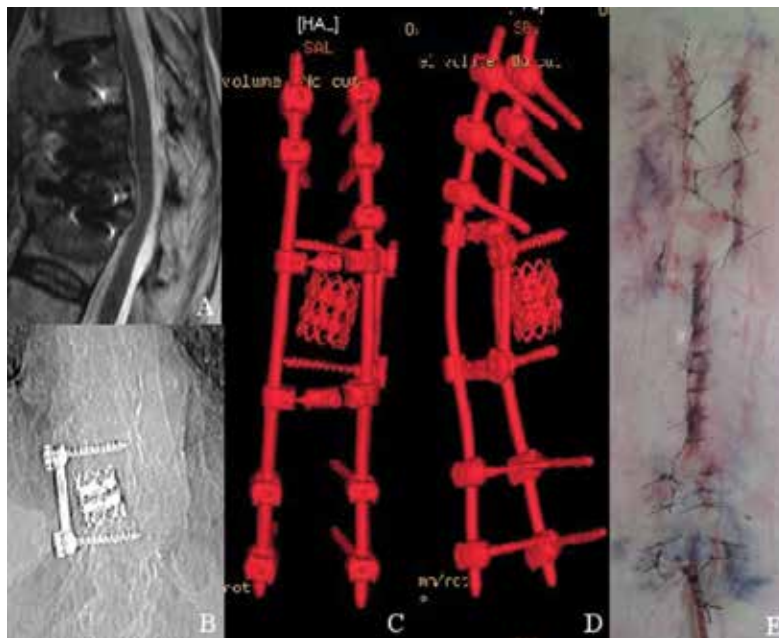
Clinical case 2. Pre-operative MRI sagittal scan and coronal thoraco-lumbar X-ray (A and B images) showed diffuse spinal metastatic localizations with pathologic fractures of T9, T10 and T11, severe kyphosis and medullary compression in patient with a previous right partial T10 corpectomy with T9-T11 antero-lateral fixation. In the C and D images it is shown the postoperative CT scan 3D reconstruction which documented the percutaneous fixation with transpedicular screws at T7, T8, left pedicle of T9, L1 and L2, followed by a mini-open access, centered at the level of T10-T11, with a decompressive laminotomy and double cross-link. Skin incisions in the F image.
